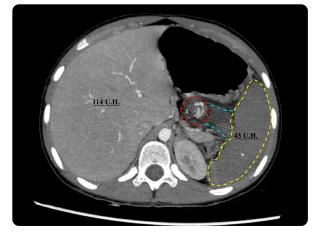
Arterial phase CT. The vascular swirl sign is observed (X), the vascular pedicle and splenic hilum without enhancement of the contrast medium as well as the spleen, the density of the liver of 114 HU is mentioned, in comparison with the spleen of 43 HU (*), with a density ratio liver-spleen greater than 2.
